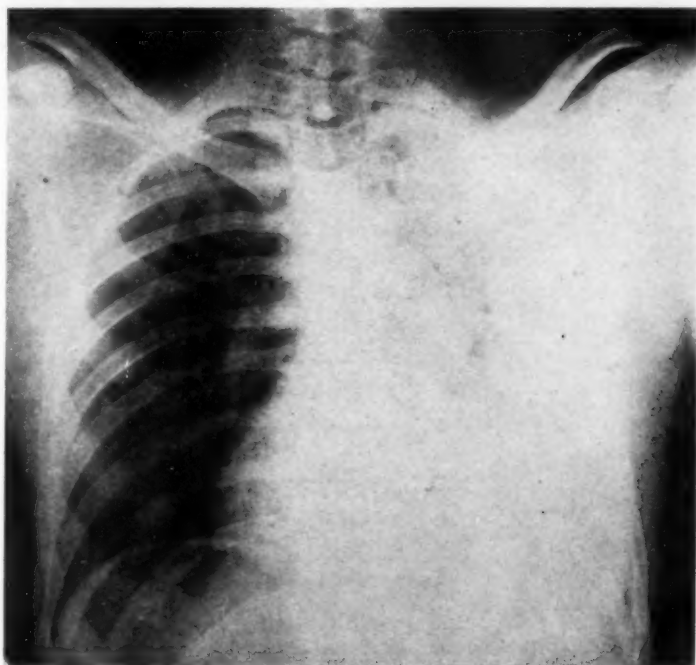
Roentgenogram of the chest taken March 24 revealing massive atelectasis of the right lung with shift of the mediastinal contents to the affected side.
